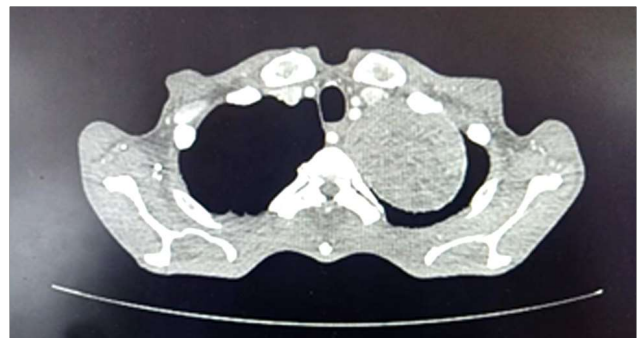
CT Thorax; Shows left apical pleural lesion
